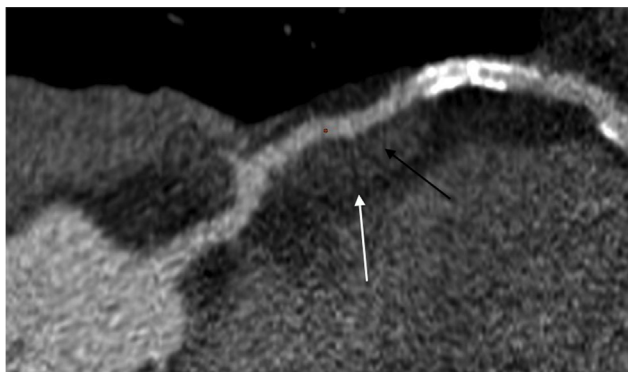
Coronary aneurysm (white arrow) with mural thrombus (black arrow). Coronary CT angiography with curvilinear reconstruction shows a local dilatation that affects less than 50% of the length of the vessel.
